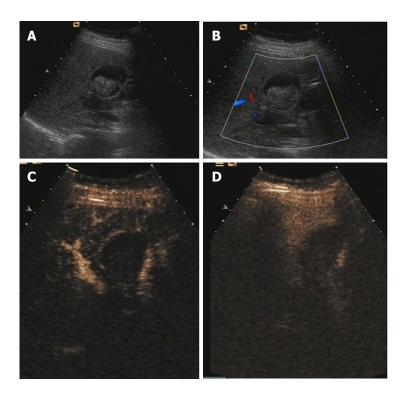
Gallbladder sludge in a 54-year-old female patient. A: B-mode sonography showed a hypoechoic, well-defined mass in the gallbladder, with an intact gallbladder wall; B: Color Doppler ultrasound showed no color Doppler signal in the lesion. According to A and B, a diagnosis of probably benign was made; C: CEUS showed complete nonenhancement on arterial phase; D: CEUS showed complete nonenhancement on venous phase. According to C and D, a diagnosis of benign gallbladder sludge was made. CEUS: Contrast-enhanced ultrasound.
